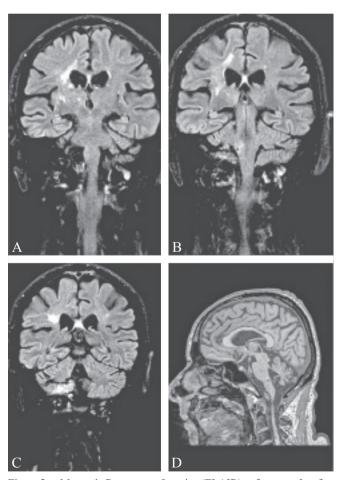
Magnetic Resonances Imagine (FLAIR) at four months after the event. Coronal (A, B), axial image (C) and sagittal (D) show an ipodense area confined to a small region of the dorsolateral medulla just anterior to the floor of the fourth ventricle and rostral to the obex.
